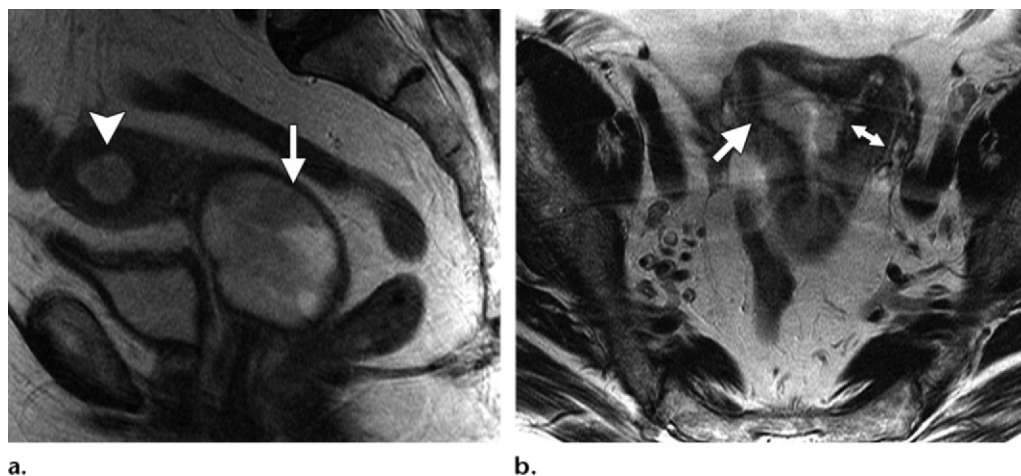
Use of two orthogonal planes along the long axis of the tumor. (a) Sagittal high-resolution T2-weighted FRFSE MR image shows a polypoid mass expanding the endometrial cavity (arrowhead) and extending into and expanding the endocervical canal (arrow). It is difficult to determine whether myometrial invasion is present. (b) Axial high-resolution T2-weighted FRFSE MR image obtained along the coronal plane of the uterus and orthogonal to the sagittal images shows broad-based myometrial invasion along the right lateral wall (arrow) that is limited to the inner one-half of the myometrium. The depth of myometrial invasion was assessed on the basis of the thickness of the contralateral wall (double-headed arrow), a finding that was confirmed at pathologic analysis.
